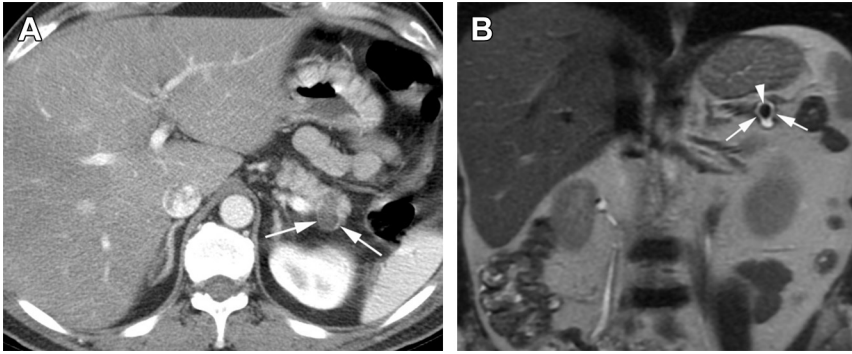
Residual small WON after necrotizing pancreatitis confused with cystic neoplasm on CT. (A) This 77-year-old man presented with right lower quadrant pain, and a CT was performed to assess for acute appendicitis. CT confirmed acute appendicitis (not shown) but also noted a cystic mass (arrows) arising from the tail of the pancreas. The patient denied ever having had acute pancreatitis. A possible cystic neoplasm was diagnosed based on an oval-shaped structure of fluid density. For further more definitive evaluation, an MR was recommended. (B) Same patient as Fig. 18A. The MR imaging shows a well-encapsulated structure of high signal intensity (arrows) that contains an area of low signal intensity (arrowhead), which could represent hemosiderin or debris. A diagnosis of WON was made, and no intervention was recommended after the chart from a remote admission to an outside hospital confirmed previous necrotizing pancreatitis without intervention.
